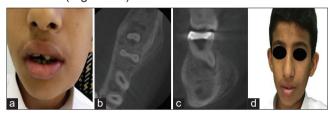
(a) Pre-operative photographs of the patient showing facial asymmetry and presence of non-painful swelling in the mandibular left posterior region. (b) Computed tomography showing radiopaque deposition mixed with radiolucency at the left mandibular buccal border. (c) Computed tomography showing radiopaque deposition mixed with radiolucency at the left mandibular lower border. (d) Follow-up of the patient demonstrating ameliorated facial appearance
